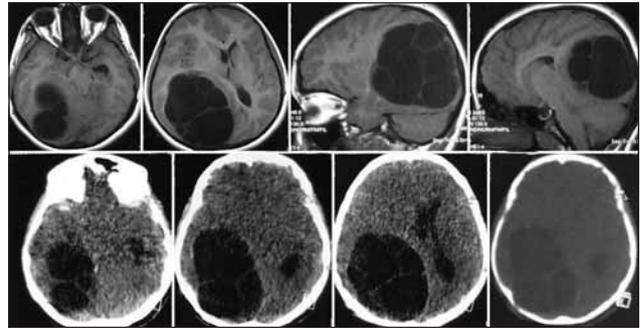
MRI of the brain (upper), showing a large mass of multiple cystic space-occupying lesions in the right parieto-occipital region, with midline shift to the left hemisphere. Edema is not seen in the surrounding brain tissue. Cerebral axial CT scan (lower), showing multiple hydatid cysts occupying the right parieto-occipital region with a thinning of occipital bone.
